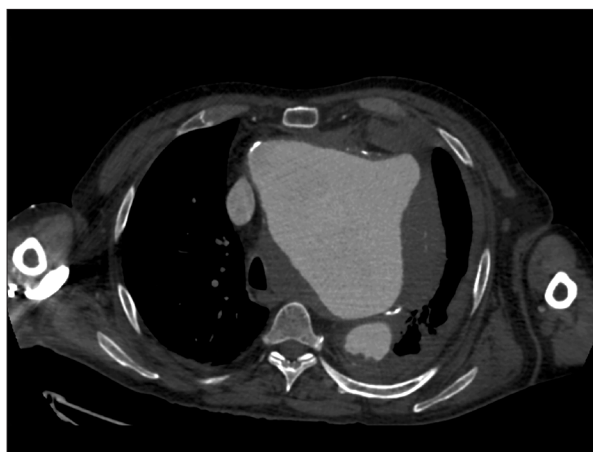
The emergency CT scan, showing visible giant aneurysm with rupture to the pleura. CT, computed tomography.
